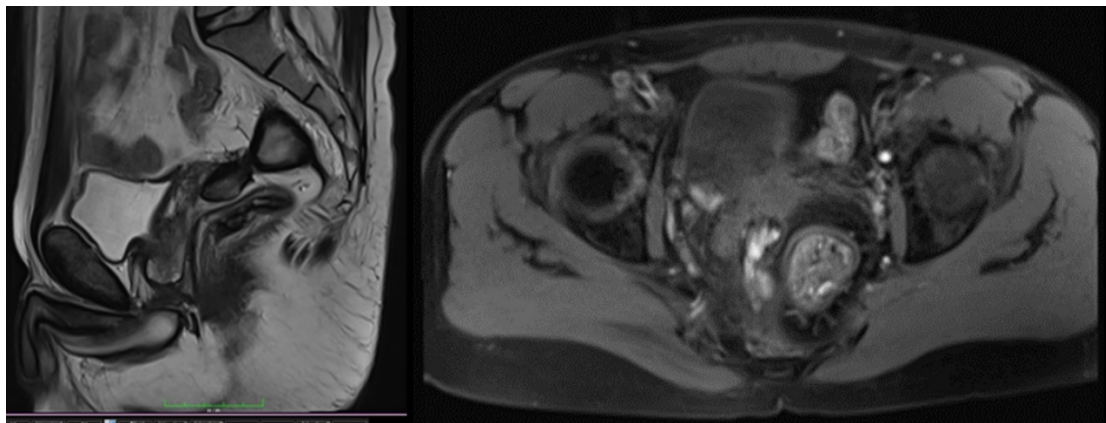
Pelvic magnetic resonance imaging: Organize of hematoma.
